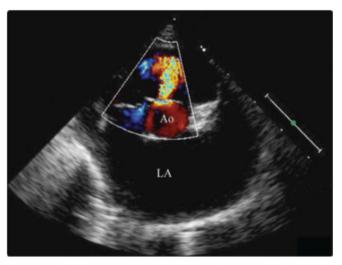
Right parasternal short-axis echocardiographic view confirming the presence of a ventricular septal defect with color-flow Doppler. Turbulent blood flow is seen entering the right ventricle from a defect located just below the aorta in the perimembranous portion of the interventricular septum. Ao, aorta; LA, left atrium.
